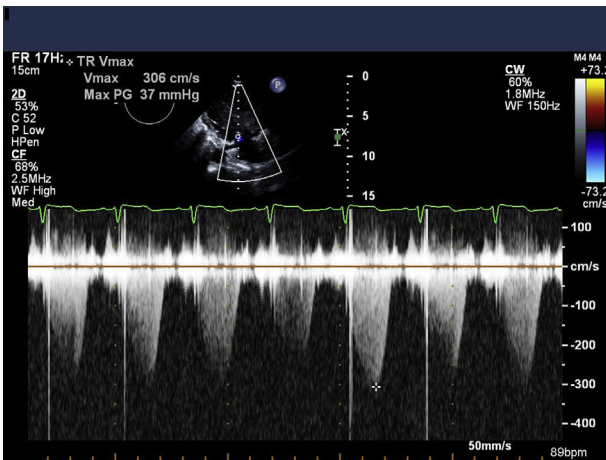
Doppler imaging across the tricuspid valve showing a peak trans-tricuspid valve gradient of approximately 47 mm Hg (assuming a right atrial pressure of 10 mm Hg).
